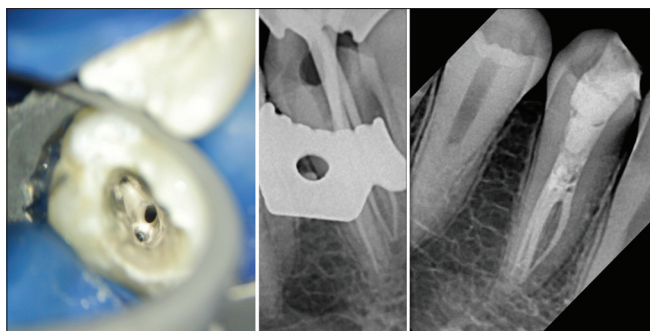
Clinical steps in the execution of complete root canal treatment with final postoperative X-ray
